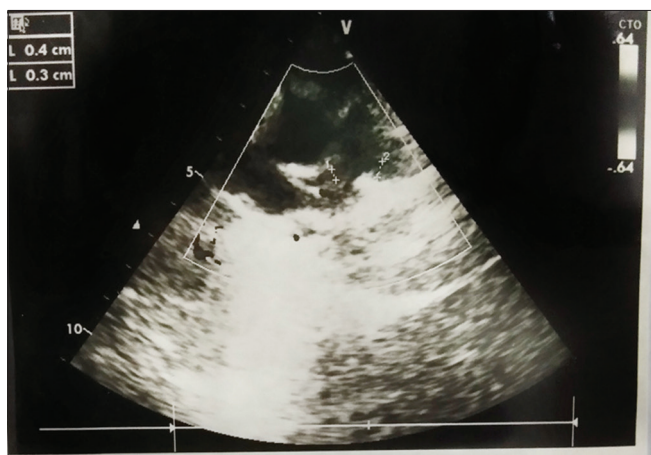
Echocardiography: Tetralogy of Fallot, severe infundibular pulmonary stenosis
